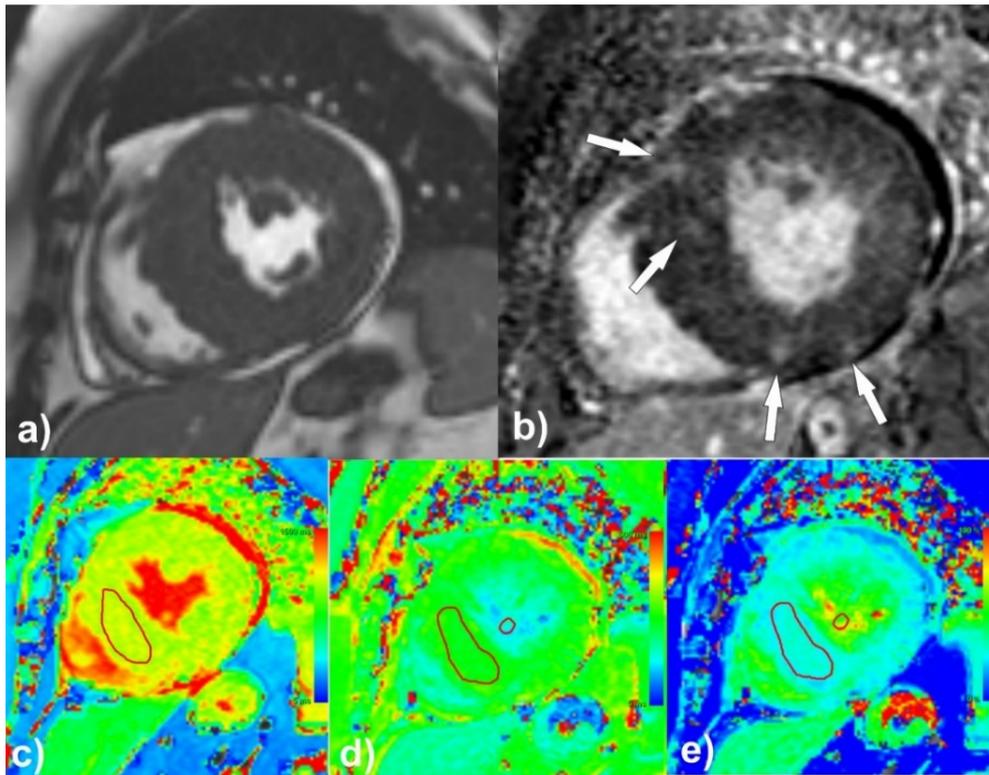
Assessment of focal and diffuse myocardial fibrosis in a 74-year-old patient with high-grade aortic valve stenosis using 1.5T Siemens Aera MRI scanner and NeoSoft SuiteHEART software.
